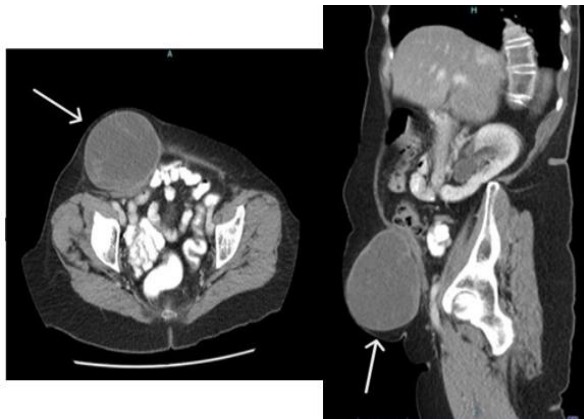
A contrasted enhanced CT of the abdomen and pelvis showed a large subcutaneous cystic lesion at the anterior abdominal wall
